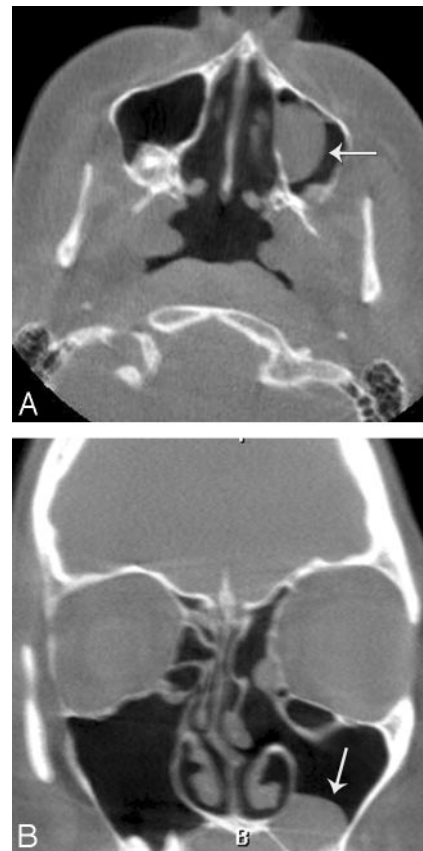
Axial (A) and coronal (B) CT scans from CT sinus study performed the day before the head trauma show a retention cyst (arrows) in the left maxillary sinus.
